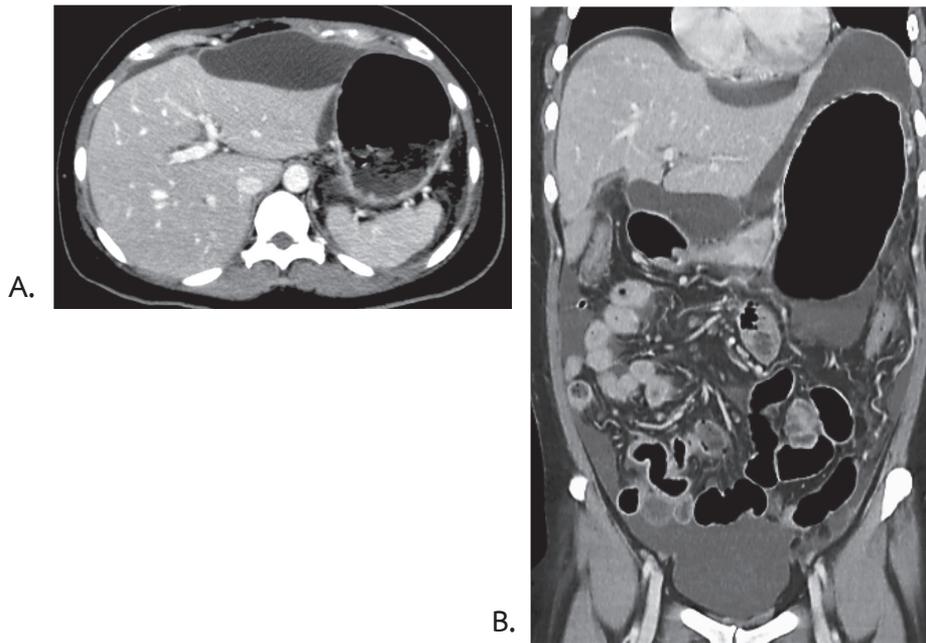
CT scan of a 42-year-old female who underwent laparoscopic cholecystectomy. (A) Axial and (B) coronal views showed large amount of intra-abdominal fluid collection. No bile duct dilatation was observed. The site of leakage cannot be demonstrated.
